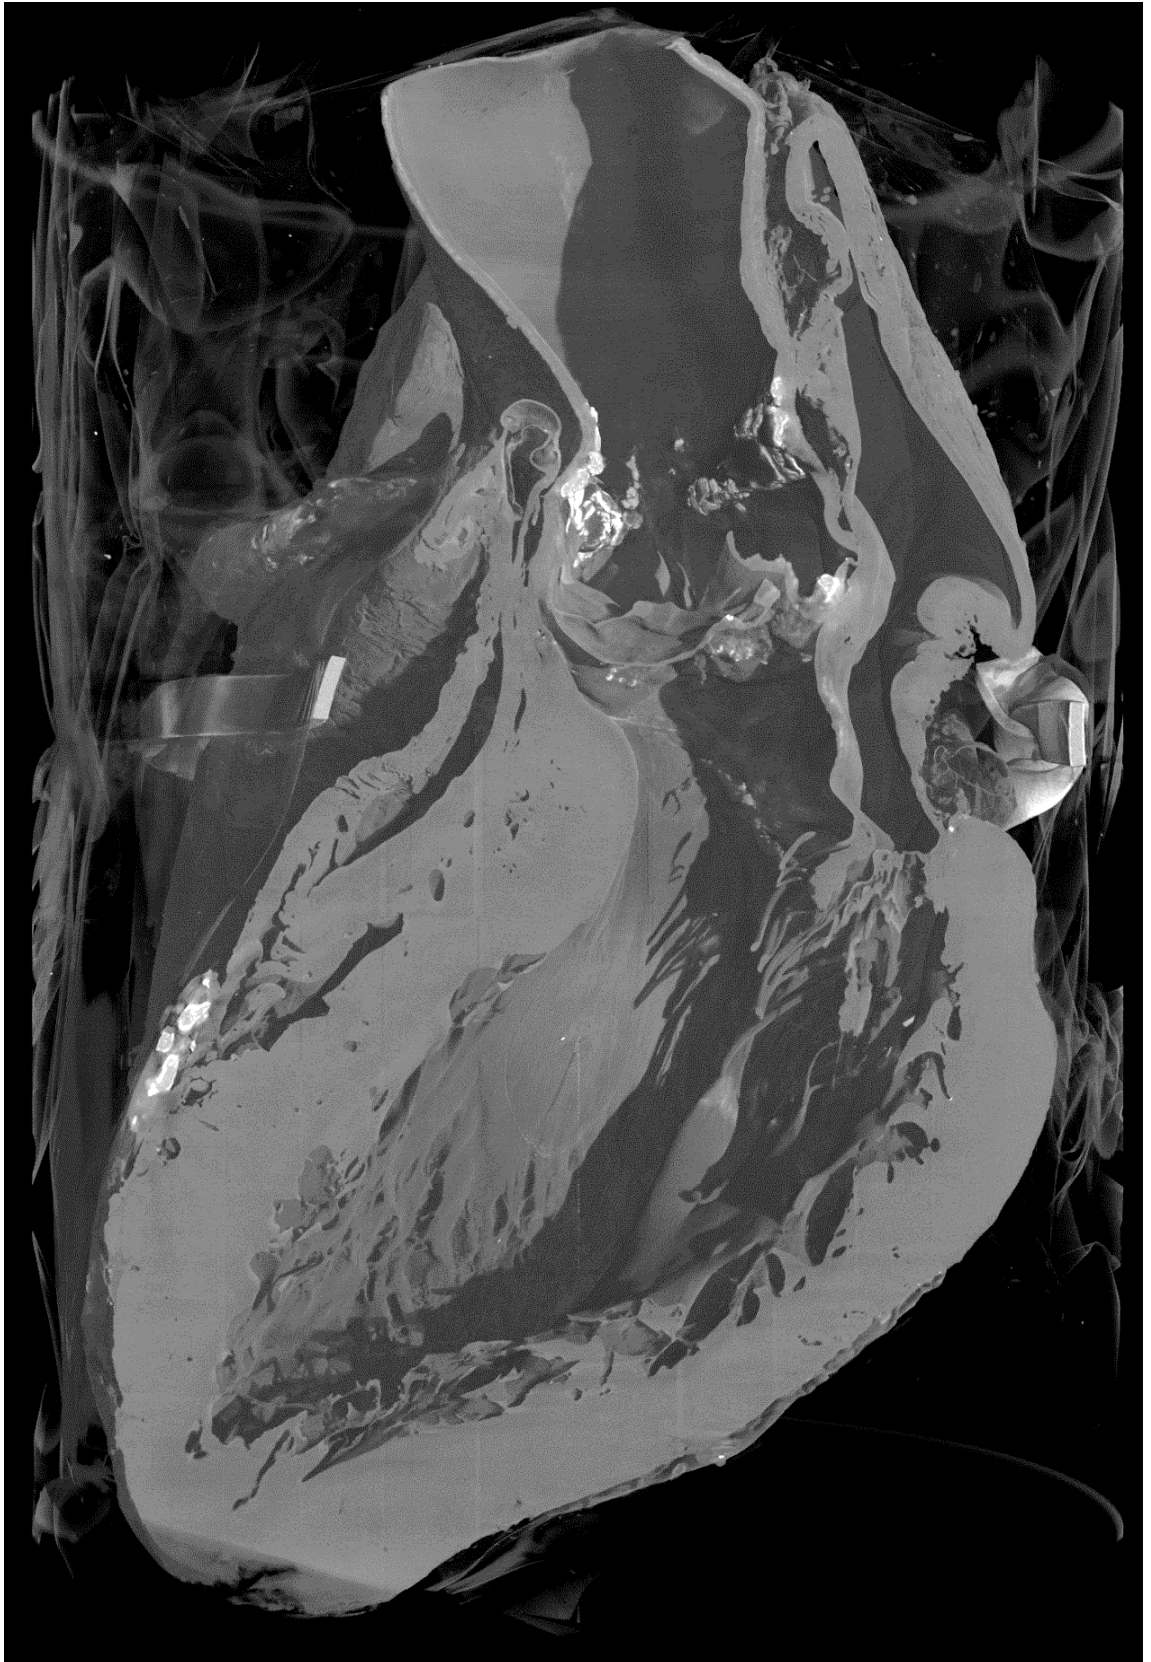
3D render of a human heart (with a section removed) based on μ CT data. The grey wisps about the heart are due to a plastic bag that could not be completely removed from the image. Furthermore an elastic band is visible encircling the heart. Bright white plaques are visible in various locations about the heart.
